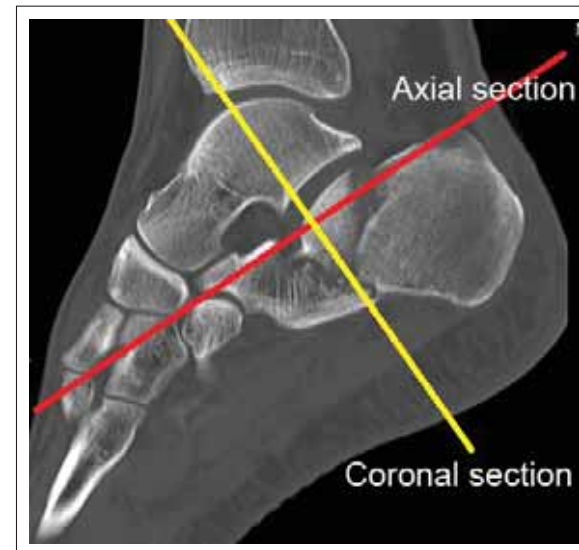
Sanders classification is based on coronal and axial CT scan sections taken at the widest undersurface of the posterior facet of the talus.
